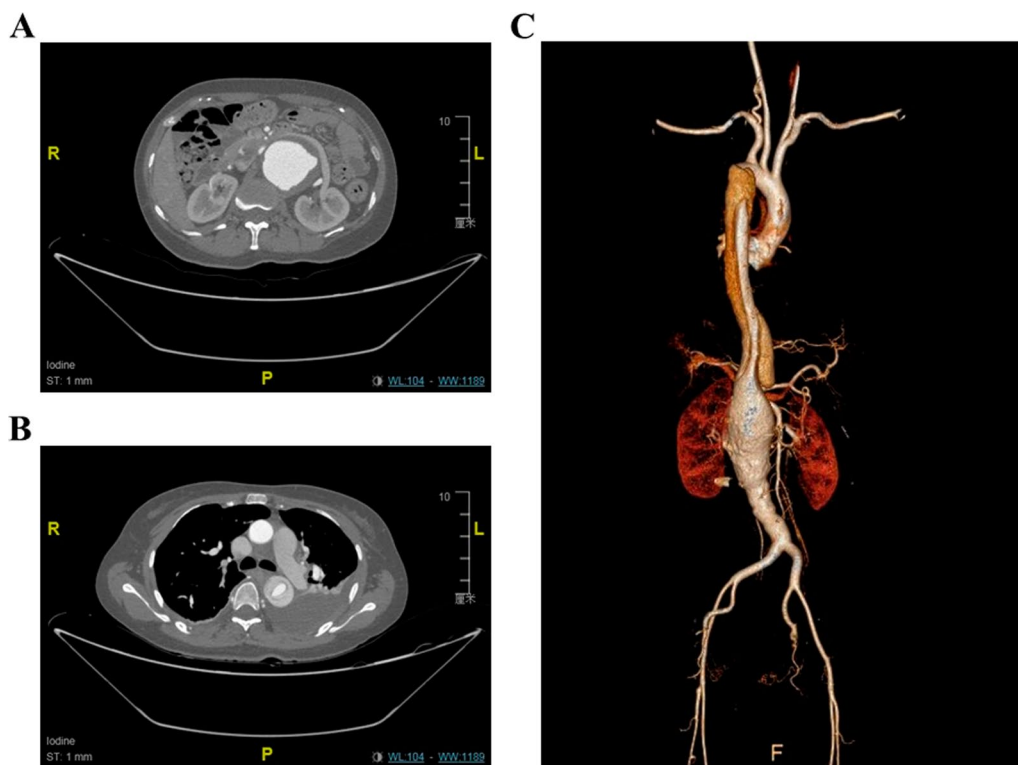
(A) Computed tomography angiography of aneurysmal abdominal aorta and (B) Type B thoracic aortic dissection with pleural effusion. (C) Three-dimensional reconstruction of aorta demonstrating coexistence of thoracic aortic dissection and abdominal aortic aneurysm
